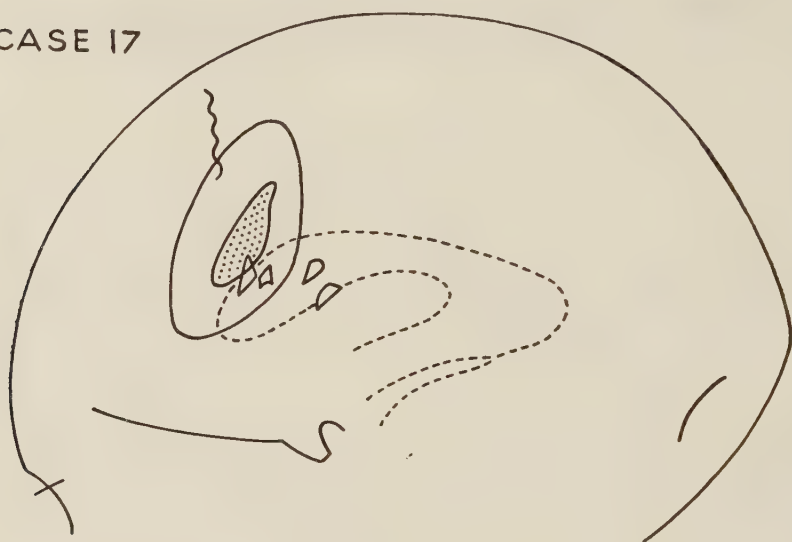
Tracings of pre-operative skull radiographs in Case 17. Bone fragments driven into the posterior part of the left frontal lobe to a depth of 5 cm.
